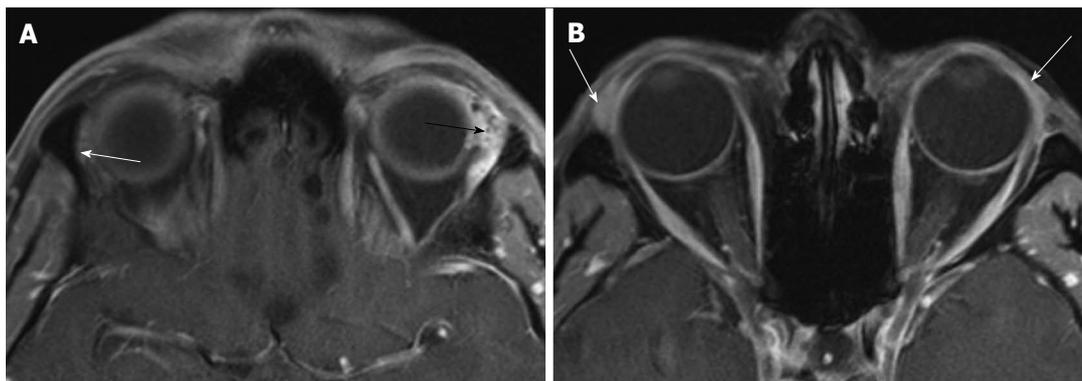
Adenoid cystic carcinoma of the lacrimal gland. A: Axial T1 non-enhanced MRI showing an enlarged, heterogeneous left lacrimal gland (black arrow). Compare this to the contralateral normal gland (white arrow); B: Axial T1 non-enhanced MRI showing sparing of the palpebral lobe (arrows). MRI: Magnetic resonance imaging.
